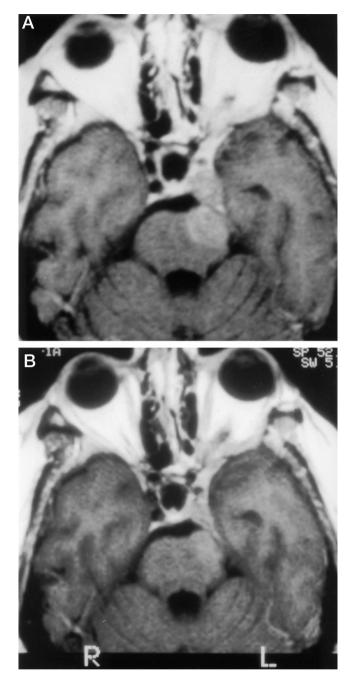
Reduction of tumor size, retrosellar (pontine) extension, and cavernous sinus invasion (computed tomography scan) in a patient with a highly aggressive prolactinoma before (a) and after (b) two courses of chemotherapy with CCNU/5-FU.
